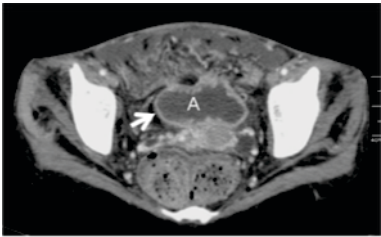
Axial CT image shows loculated ascites (A) with enhancing peritoneum in the pelvis (arrow)
